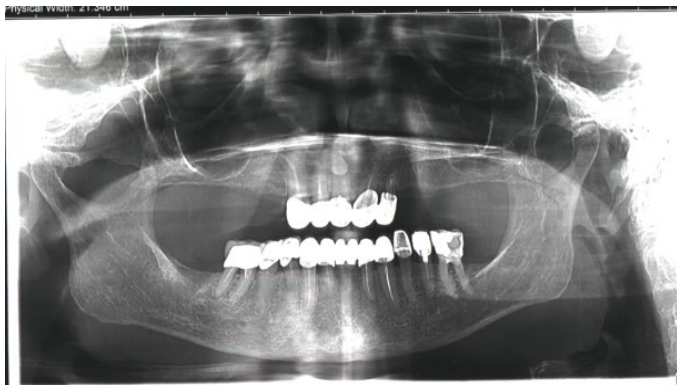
OPT X-ray. T-T maxillary edentation, T-T mandibular edentation. Radiological image details: the marginal and interradicular alveolar bone defects are visibly remineralized; apically, it is still minimally visible in tooth 4.6 as well as tooth 3.3, where it is slightly more pronounced, which indicates in this case an asymptomatic apical reaction of endodontic etiology. X-ray taken eight weeks after initiation of pulsed short wave therapy. The X-ray in Fig. 6 shows advanced remineralization of maxillary and mandibular alveolar bone structures eight weeks after the onset of pulsed short wave therapy and closed periodontal curettage.
